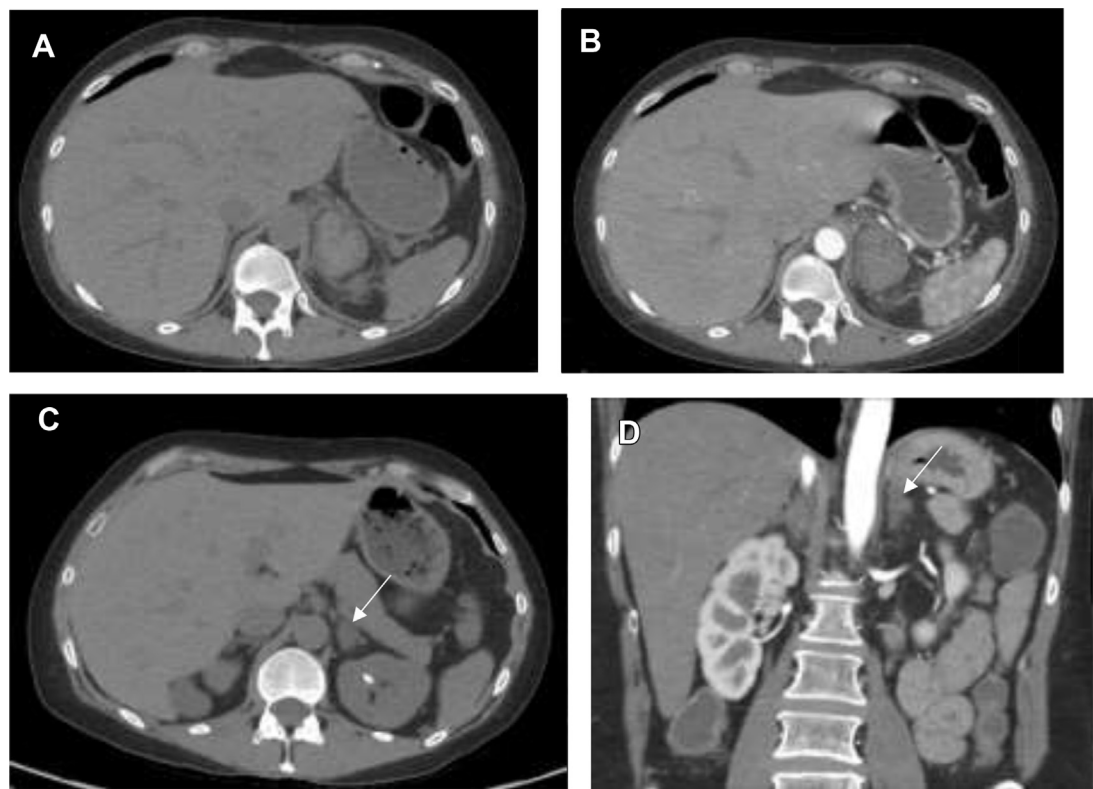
A 51-year-old patient presented to the emergency department with abdominal pain. Axial unenhanced CT (A) and axial image of contrast-enhanced CT (B) demonstrate a well-circumscribed, rounded 3.2×4.2 cm mass involving the left adrenal gland with attenuation of 51 HU and no significant postcontrast enhancement, suggestive of hematoma. In the following 3 months, the patient had adrenal insufficiency symptoms in the form of fatigue, abdominal pain, and weakness. The workup for adrenal bleeding showed a heterozygous factor V Leiden mutation. Axial unenhanced CT (C) and coronal reformatted images of contrast-enhanced CT (D) performed 3 months later for follow-up showed interval resolution of the hematoma with diffuse left adrenal gland thickening (arrow).
